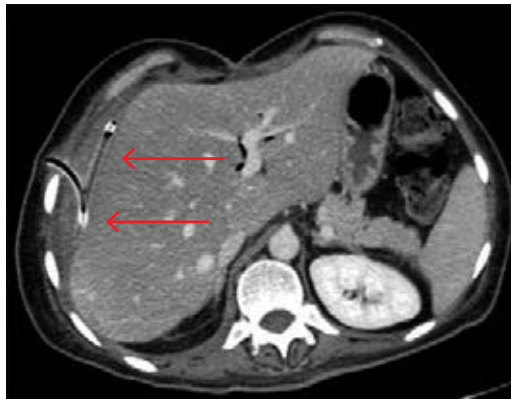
Post-drainage abdominal CT scan; it shows that 80% of the hematoma was drained (arrows).
